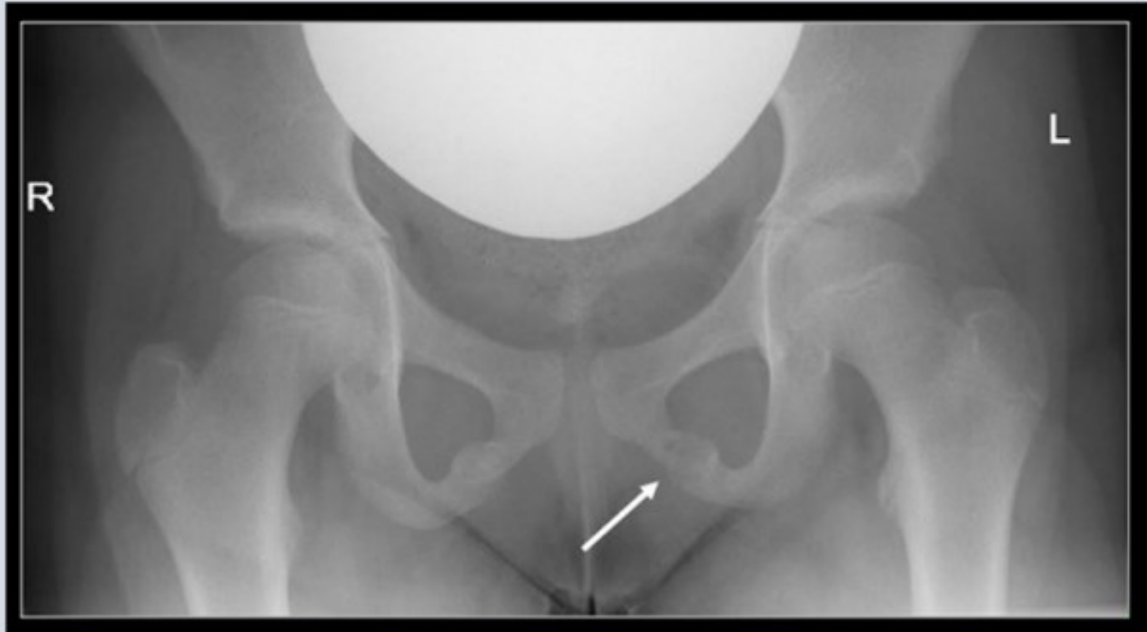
Anteroposterior radiograph of the pelvis reveals expansion of bilateral ischiopubic synchondrosis and a well-appreciable lucent appearance on the left (arrow).
